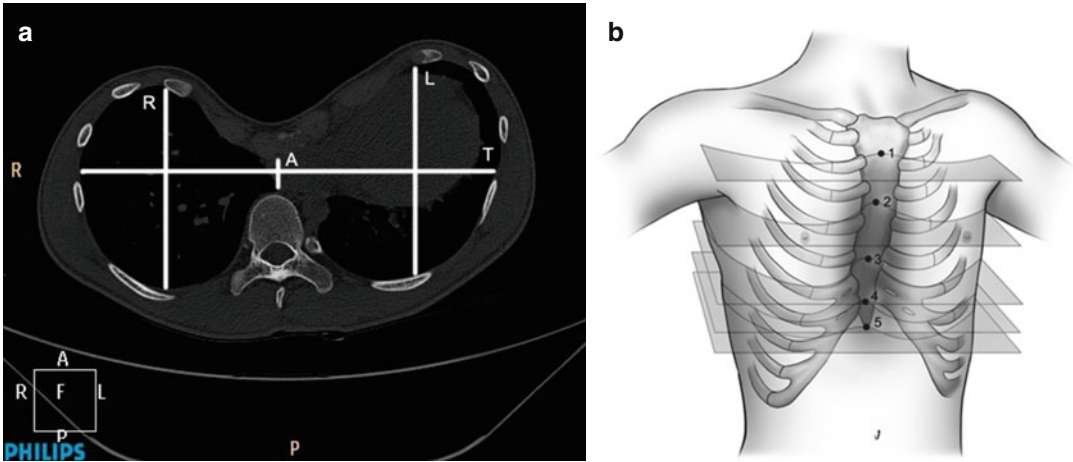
(a) Axial CT Scan of a patient with PE. Calculation of the Haller Index and Asymmetry Index. Ref: [T] transversal chest dimension; [R and L] sagittal right and left chest size dimensions; [A] sternovertebral distance. (b) 5-position protocol for intrathoracic measurement of Haller Index and Asymmetry Index at each cut level. Position 1: the level of the sternomanubrial
